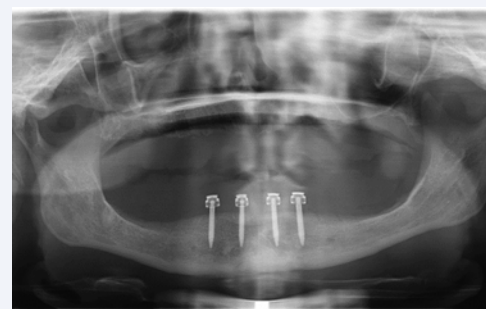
Radiographic view of MDIs.
